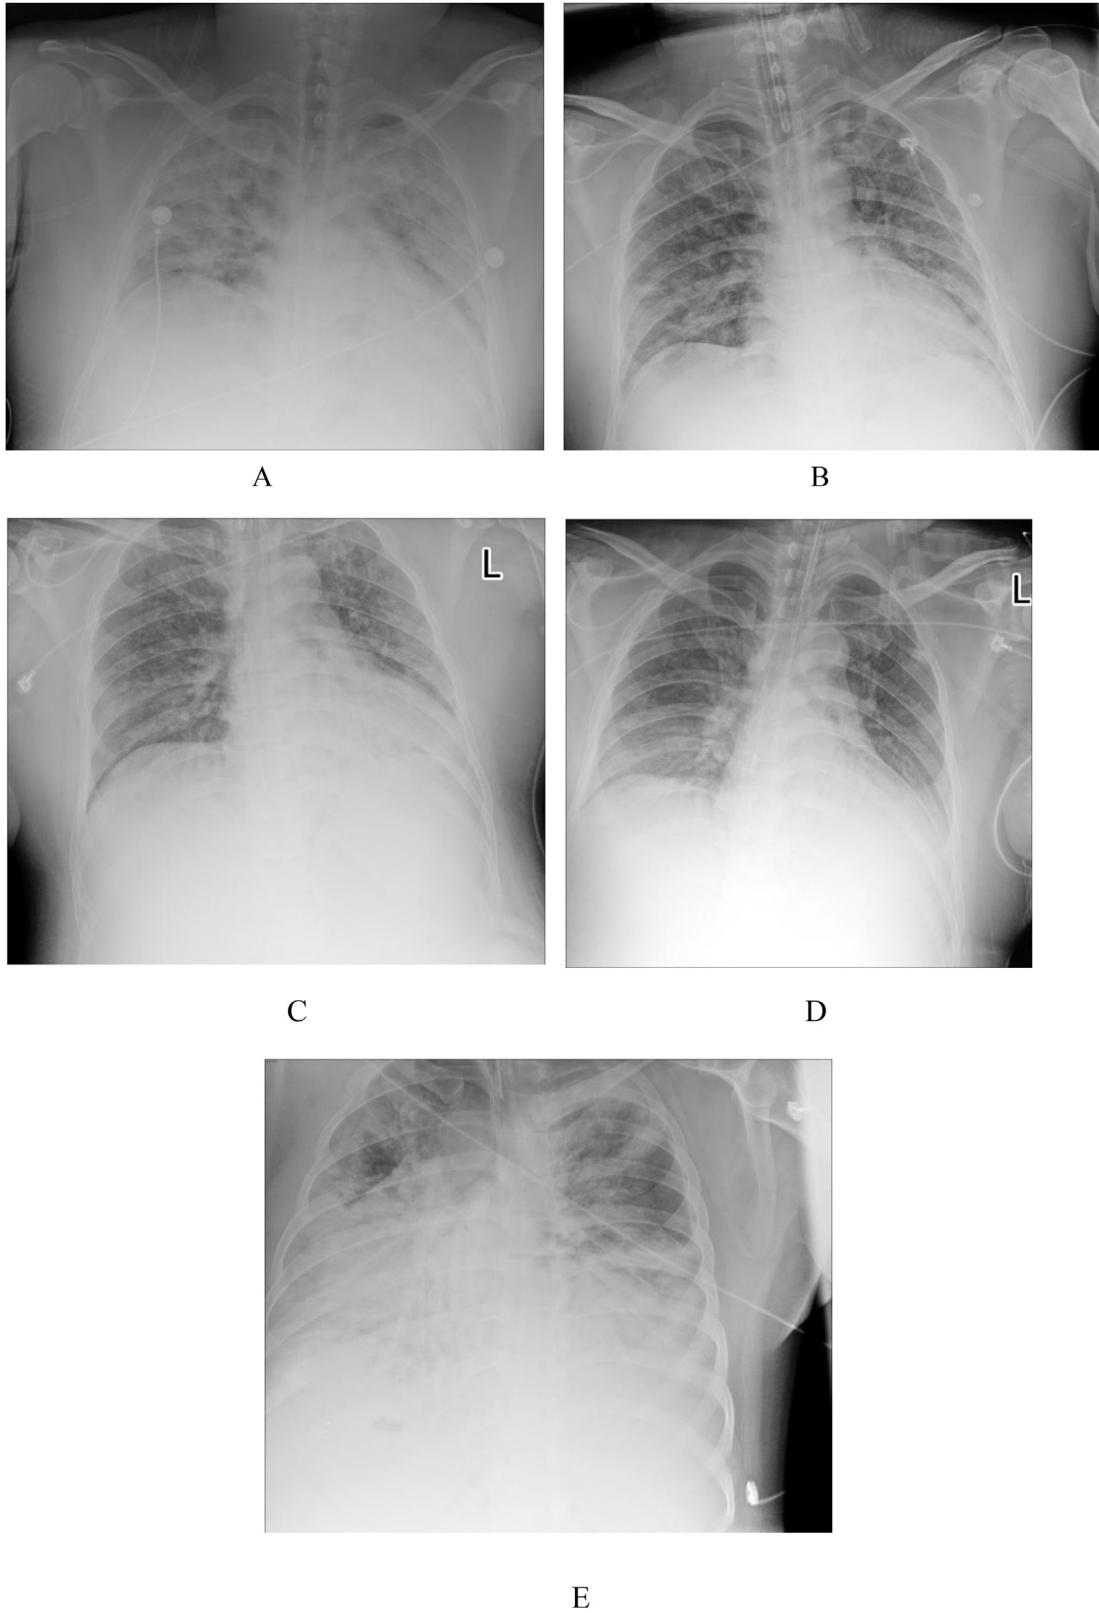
A series of bedside chest radiographs of the patient. A, On hospital day four, multiple patchy consolidation lesions appeared in bilateral lungs; B, On hospital day five, consolidation lesions partially absorbed than the previous day; C, On hospital day six, consolidation lesions slightly absorbed than the previous day; D, On hospital day nine, most of the consolidation lesions were absorbed; E, On hospital day 12, multiple consolidation lesions suddenly appeared in bilateral lungs.
